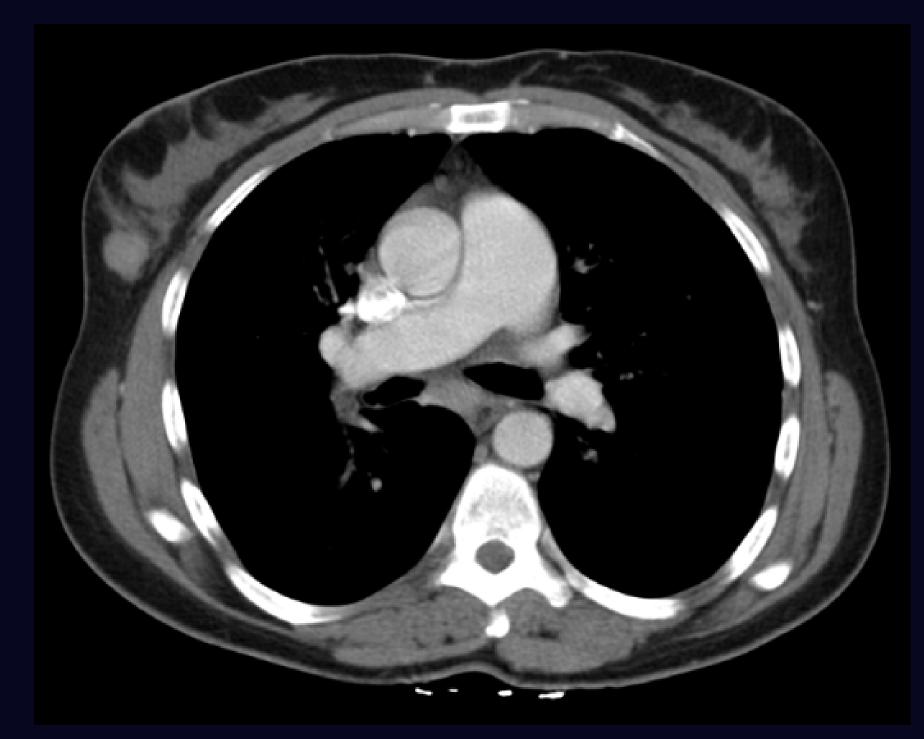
Axial CT image of a woman in the emergency department with chest pain demonstrating an incidental right breast mass. Optimal assessment with mammogram and/or ultrasound at a breast care center is recommended however a emergency department breast ultrasound study may be obtained.
